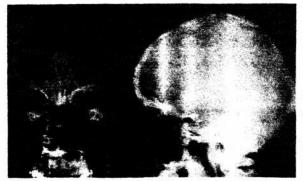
Anterior-posterior and lateral skull X-rays of Patient BP-31 after first electrode placement. Note that the superior electrodes are posterior.
